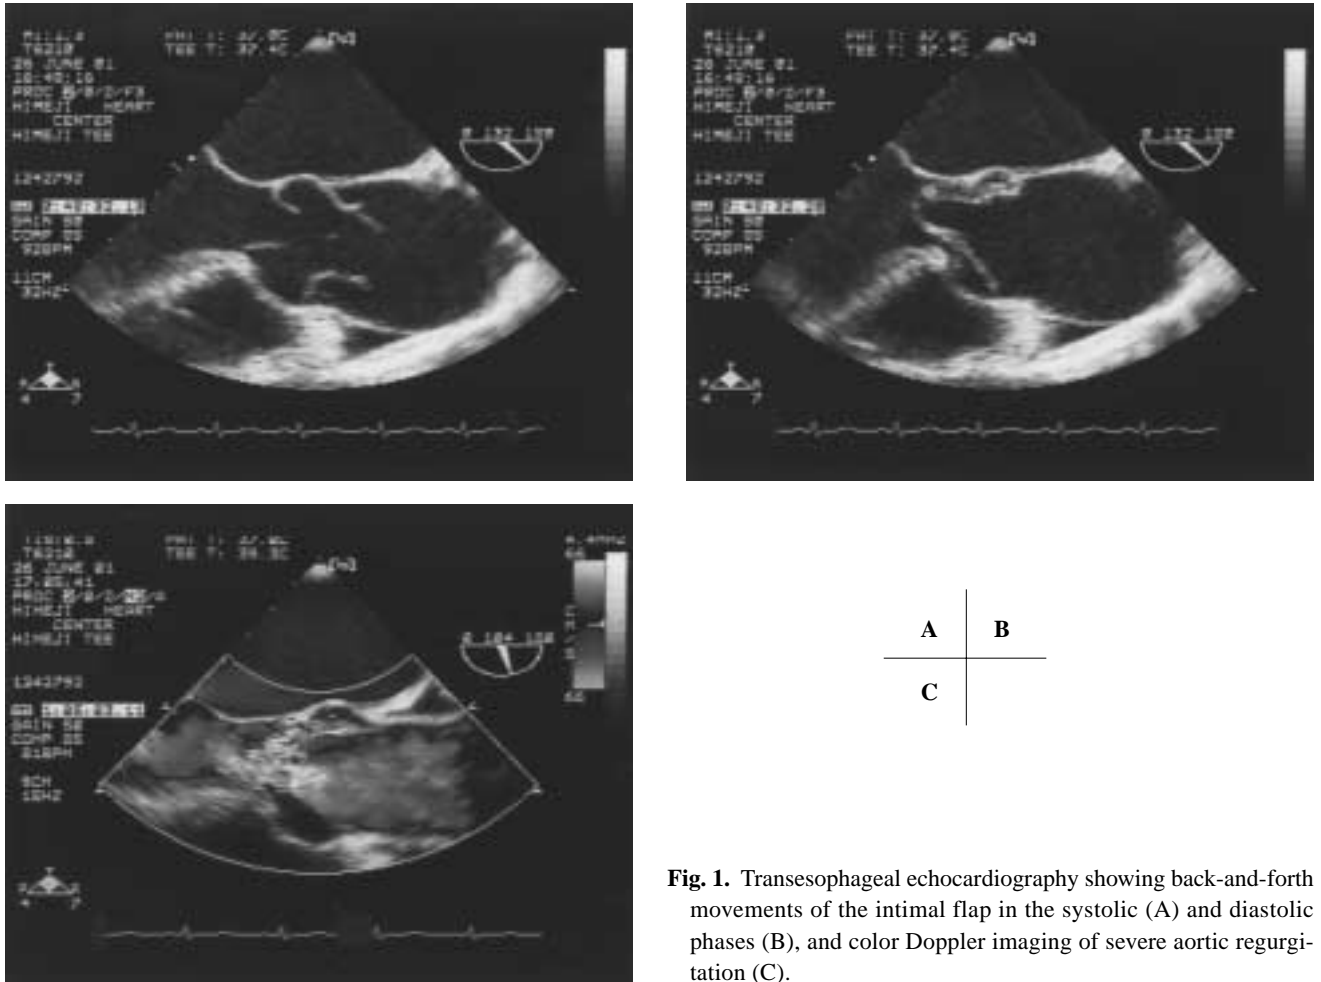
Transesophageal echocardiography showing back-and-forth movements of the intimal flap in the systolic (A) and diastolic phases (B), and color Doppler imaging of severe aortic regurgitation (C).
